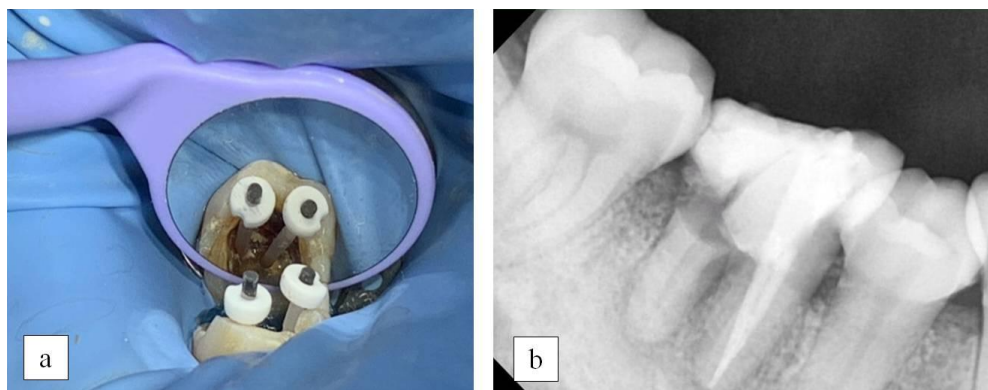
(a) Fiber post inserted into the canal; (b) Radiographic photo confirming fiber post insertion.
